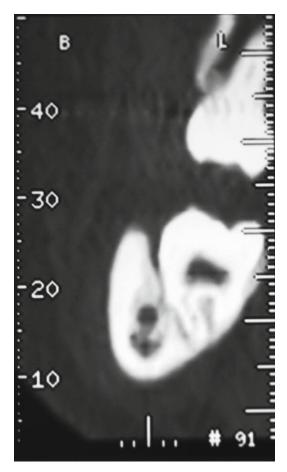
CT of a L3M depicts a mandibular canal close to the buccal CEJ. Removal of the buccal bone should be performed with extreme caution, as it can decorticate and eventually injure the mandibular canal, although it is not in contact with the tooth. In this case CT offers important information to plan the operation
